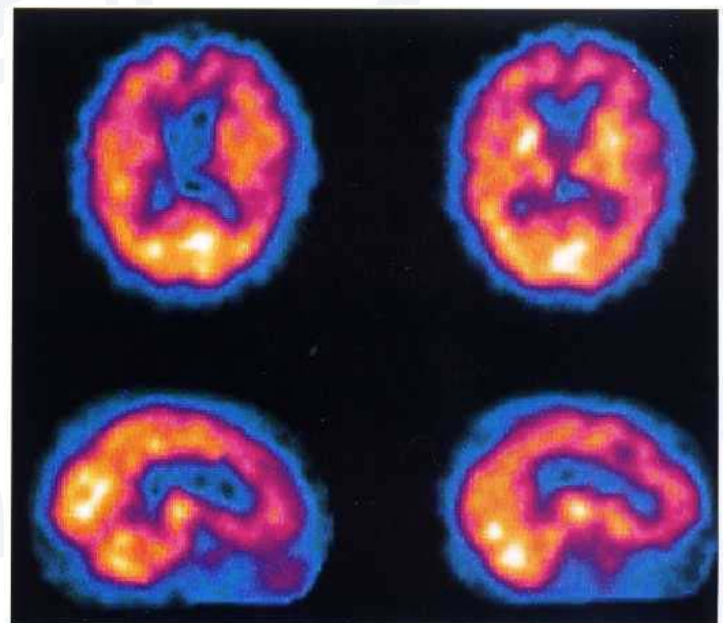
^{91m}Tc -exametazime brain SPECT: axial (top row) and left and right parasagittal (bottom row) sections in a patient with dementia of frontal lobe type. Note the ischaemic lesions are predominantly in the frontal lobes on both sides.
